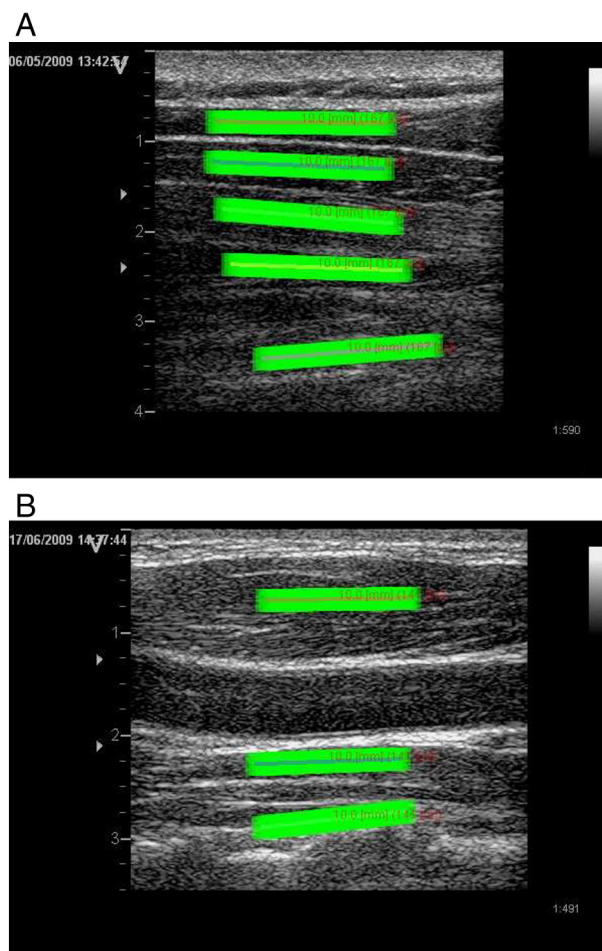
A, Longitudinal ultrasound projection of the dorsal neck muscles with ROI added on top of the muscle imaging. The following muscles were included (from most superficial to deepest): trapezius, splenius capitis, semispinalis capitis, semispinalis cervicis, and multifidus. B, Longitudinal ultrasound projection of the ventral neck muscles with ROI added on top of the muscle imaging. The following muscles were included (from most superficial to deepest): sternocleidomastoid, longus capitis, and longus colli. (Color version of figure is available online.)
